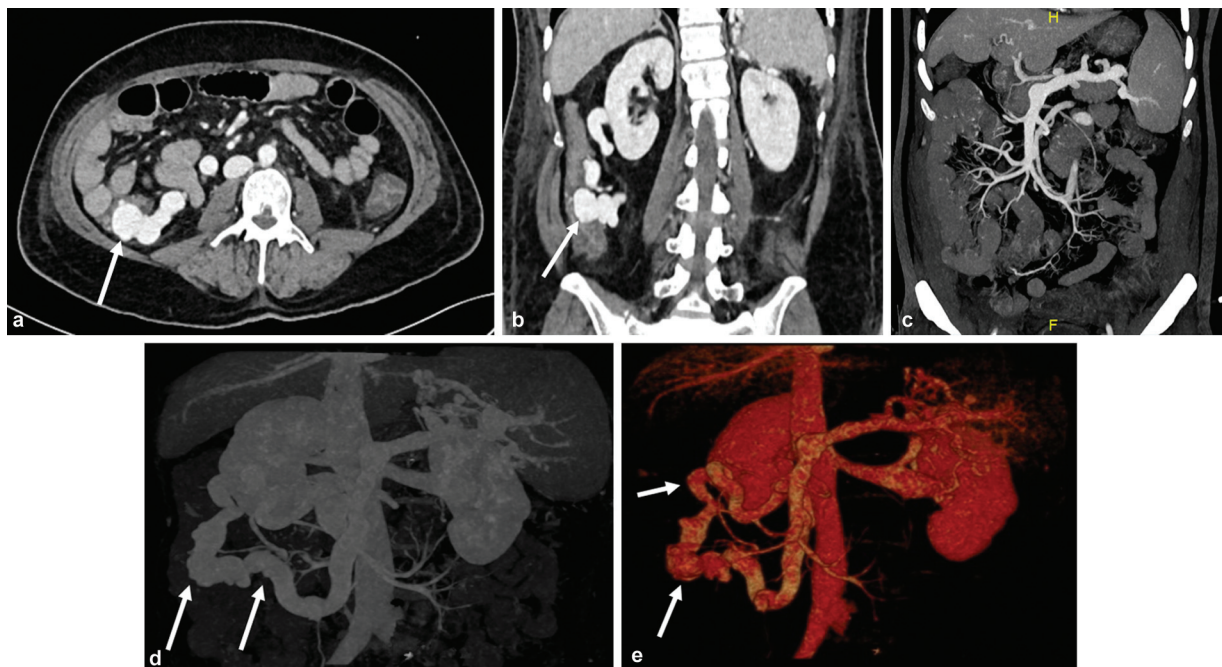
(a) Axial and (b) coronal computed tomography (CT) of the abdomen showing the abnormal shunt protruding into the lumen of the ascending colonic (*arrow*). (c) Nonopacification of the portal vein and its branches. Note the round contour of the (d) superior mesenteric vein (SMV) and splenic vein confluence and (e) showing the entire shunt arising from SMV and joining right renal vein, on a 3D reconstructed CT angiography (*arrows*).
